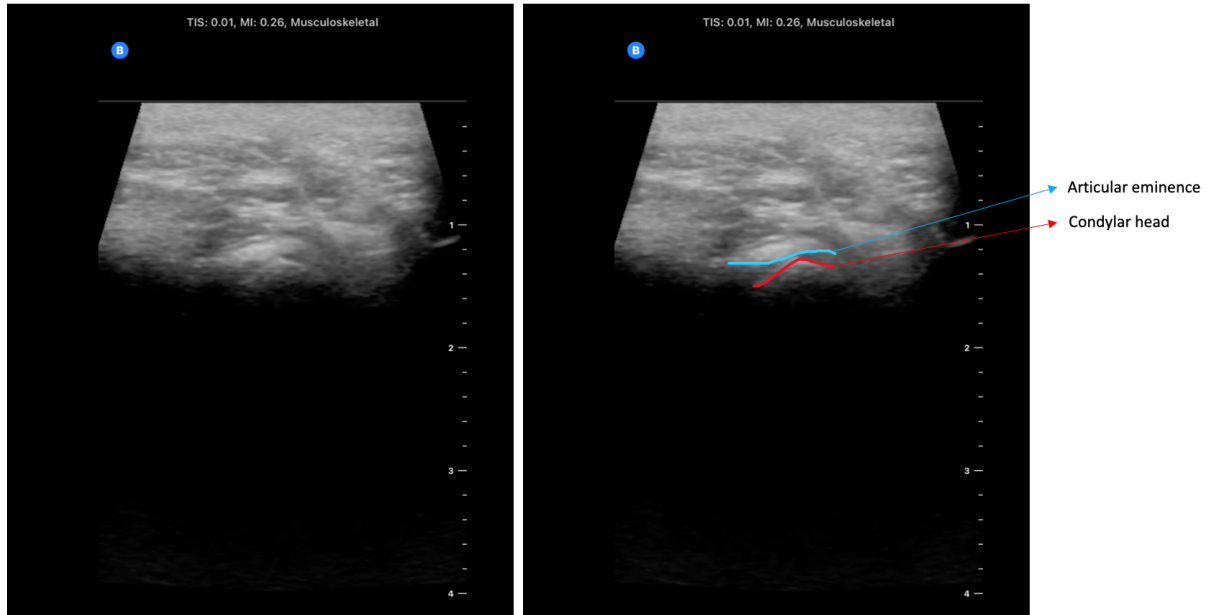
Ultrasound demonstrating osteoarthritic changes. Ultrasound demonstrating osteoarthritic changes of TMJ in closed mouth position. Note the reduced joint space and irregularly shaped condylar head, thought to represent lipping.
